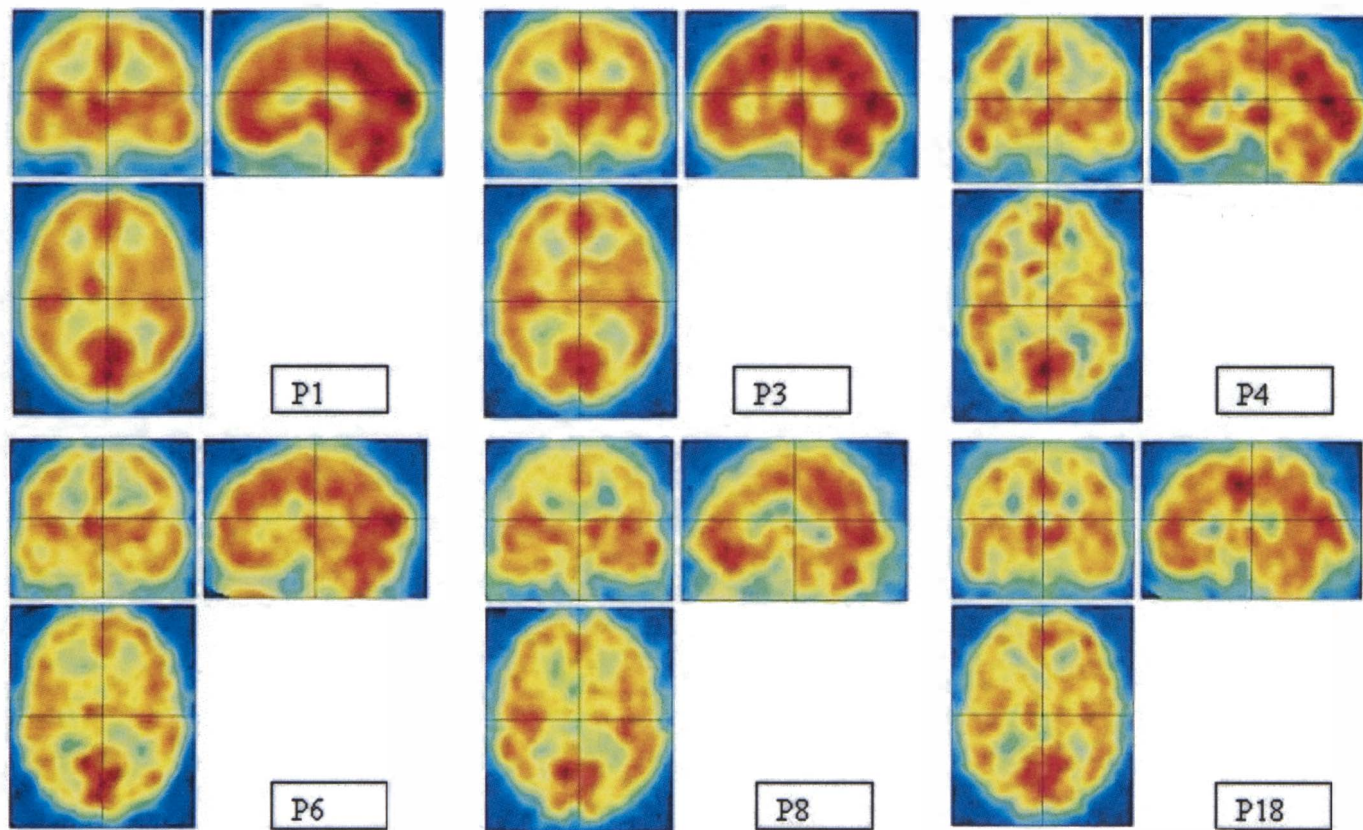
Normalized SPECT brain images for selected normal male patients using SPM (Patients 1, 3, 4, 6, 8 and 18 (Pj)).
